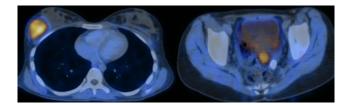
PET-CT shows a hyperdense lesion in right breast with an SUVof 5.6
